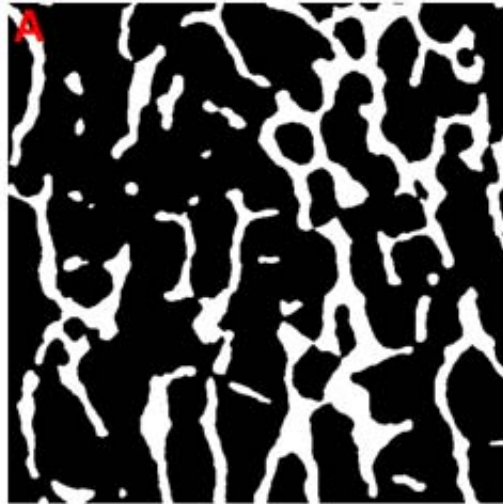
[A] Binary  $\mu$ CT tomograph of human trabecular bone, [B] Polar plot of the surface distribution (anisotropy) of the structure shown in [A] measured using the PMIL. The polar plot is shown in degrees.
